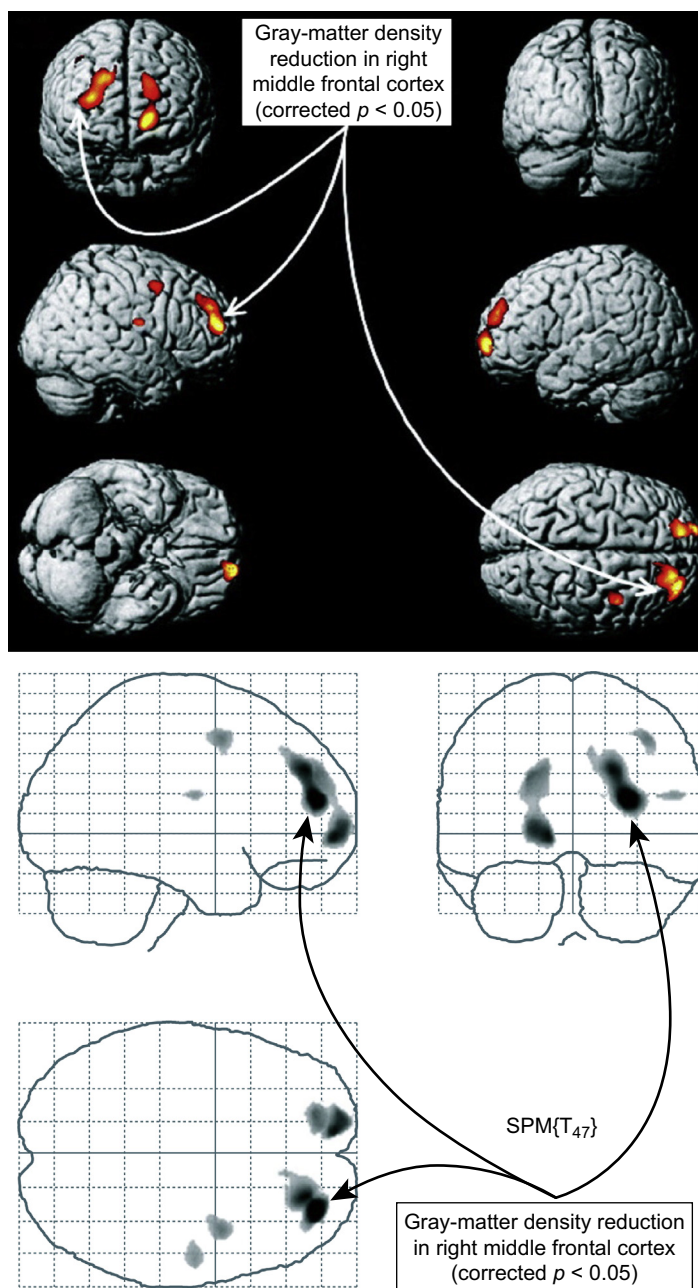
MRI: methamphetamine reduces gray matter. The yellow and red area in the central brain view indicates a reduced gray-matter density in the right middle frontal cortex. The same deficit is shown from other perspectives in the flanking views. *Reprinted with permission from Kim et al. (2006).*
